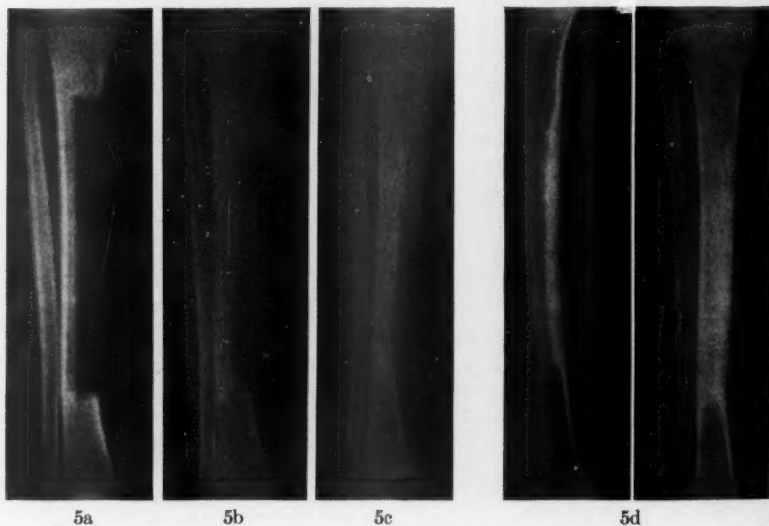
Roentgenogram of the donor tibia May 10, 1952, three weeks after removal of the graft.
